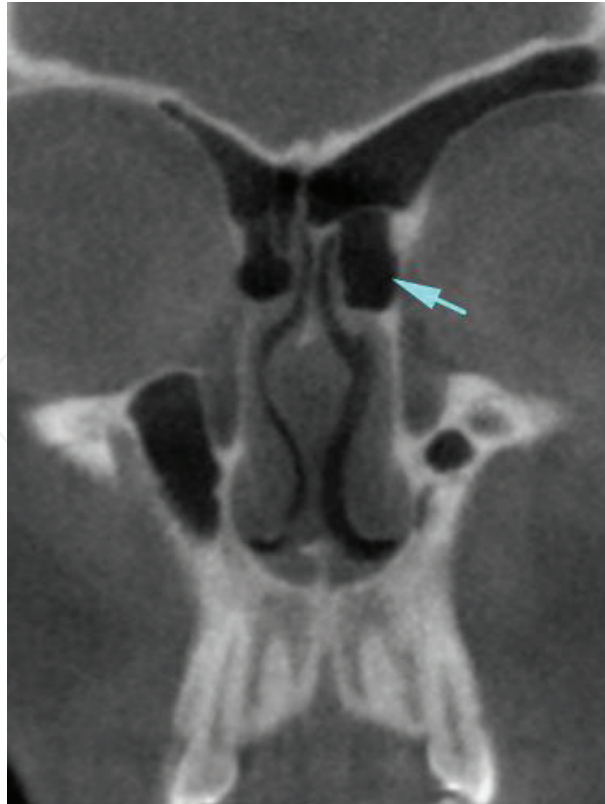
Coronal CBCT showing large ANC (arrow) on the left side which narrows the FR.
